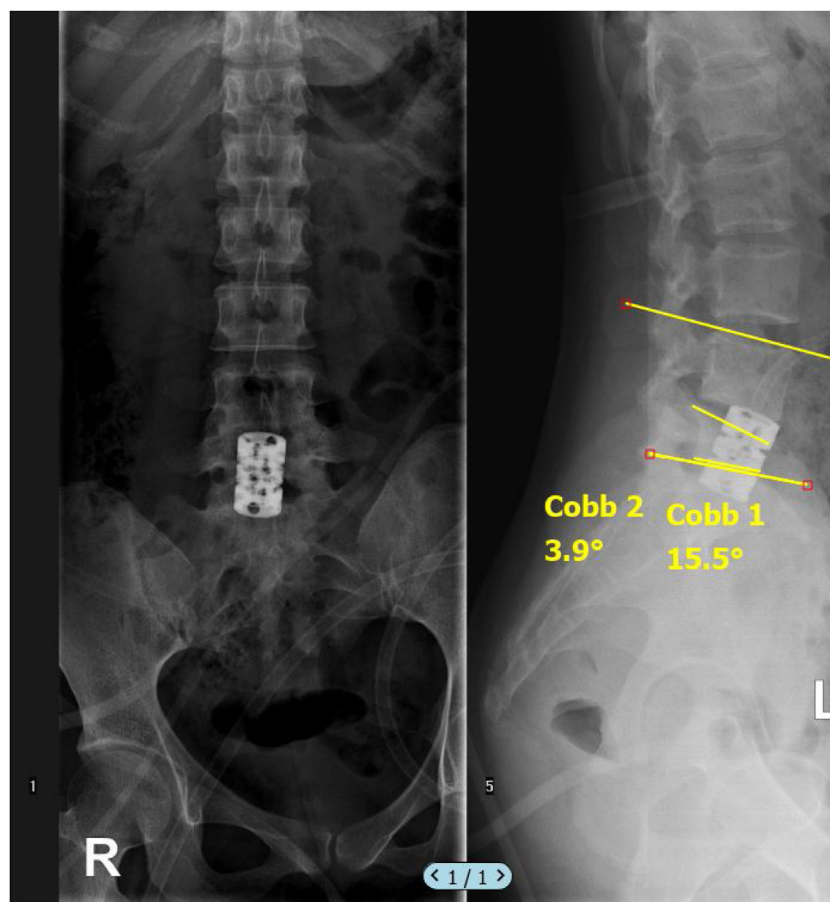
Six months Postoperative Radiograph. Expandable mesh was visible through x-ray examination. The local kyphotic angle is 15.5° and regional kyphotic angle is 3.9°.
